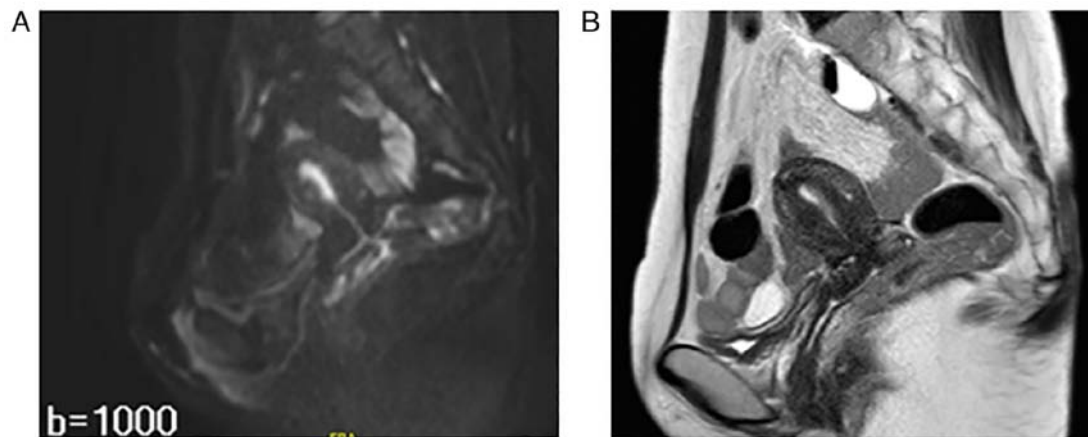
MRI results. (A) MRI diffusion-weighted image (b=1,000) revealing a high intensity in the endometrium, whereas (B) the myometrial invasion was not observed in the T2-weighted image.
